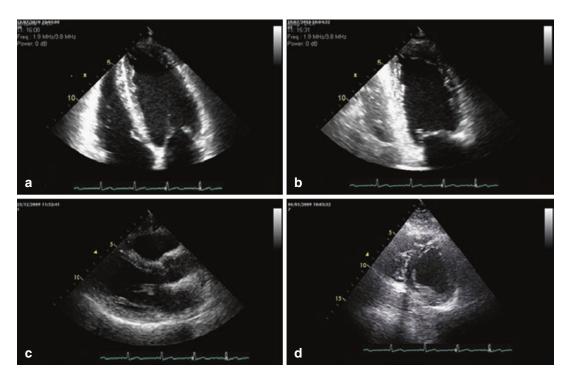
Main TTE views used for evaluation of AMI. Four chamber (a), two chamber (b), parasternal short axis (c), parasternal long axis (d)
